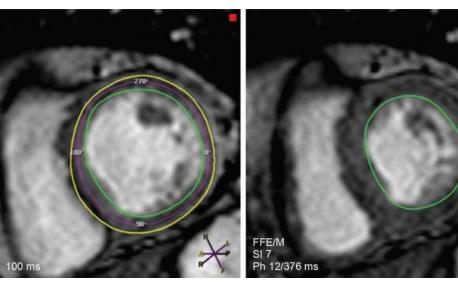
MRI measurement of left ventricular volumes, function, and mass. Endocardial (green) and epicardial (yellow) contours are shown.
